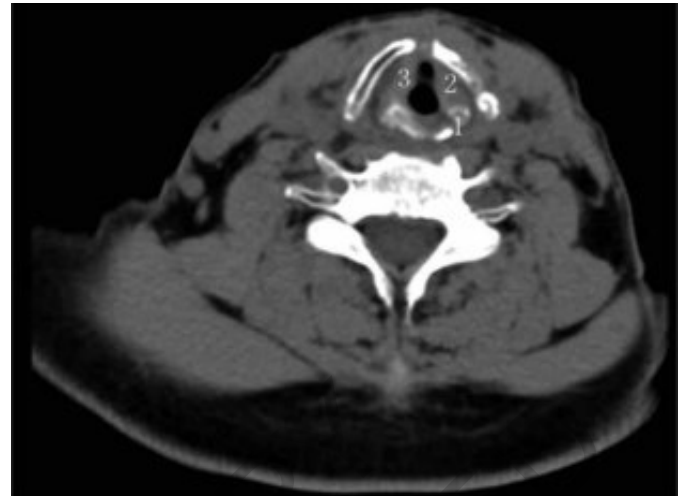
Laryngeal CT at 2 years after surgery: 1 left cricoarytenoid joint; 2 left vocal cord left; 3 right vocal cord reconstructed by epiglottis.
